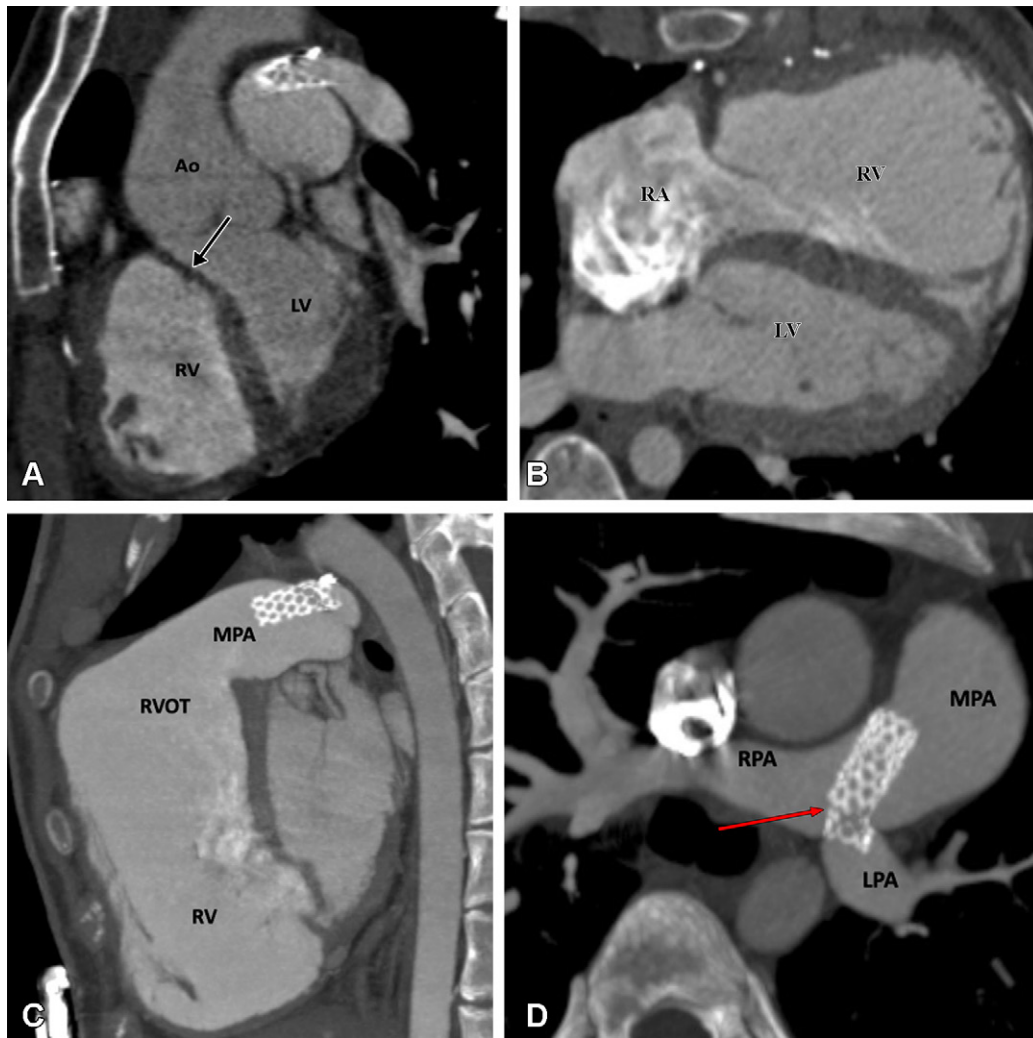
Postoperative appearance of tetralogy of Fallot after total correction and LPA stent placement in a 17-year-old girl. (A) Sagittal oblique maximum intensity projection (MIP) CT image shows a VSD patch (black arrow). (B) Axial oblique MIP CT image shows grossly dilated RA and RV. (C) Sagittal oblique MIP CT image shows dilated RV and RVOT. A patent stent is seen in the MPA extending into the LPA. Stent placement was performed to relieve recurrent LPA ostial stenosis. (D) Axial oblique MIP CT image shows a patent stent in the distal MPA extending into the LPA. There is proximal migration of the stent with fracture in stent scaffold integrity (red arrow), suggesting stent fracture. Ao = aorta, LPA = left pulmonary artery, LV = left ventricle, MPA = main pulmonary artery, RA = right atrium, RPA = right pulmonary artery, RV = right ventricle, RVOT = right ventricular outflow tract, VSD = ventricular septal defect.
